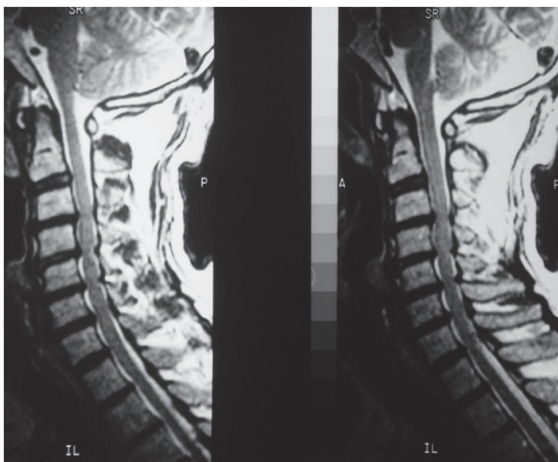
(Left). MR images on sagittal view discerned degenerative cervical disc disease and spondylosis. Patients had preserved anterior subarachnoid space in spite of anterior segmental compression and patients with posterior compression findings were excluded from the study.
